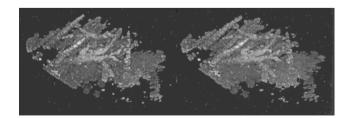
A stereo image pair from a color Doppler energy (CDE) acquisition from a liver in a normal volunteer. The color velocity data has been extracted from the volume and rendered using the interactive renderer shown in Figure 10. The full gray-scale and color data are viewable in the orthogonal planes.
